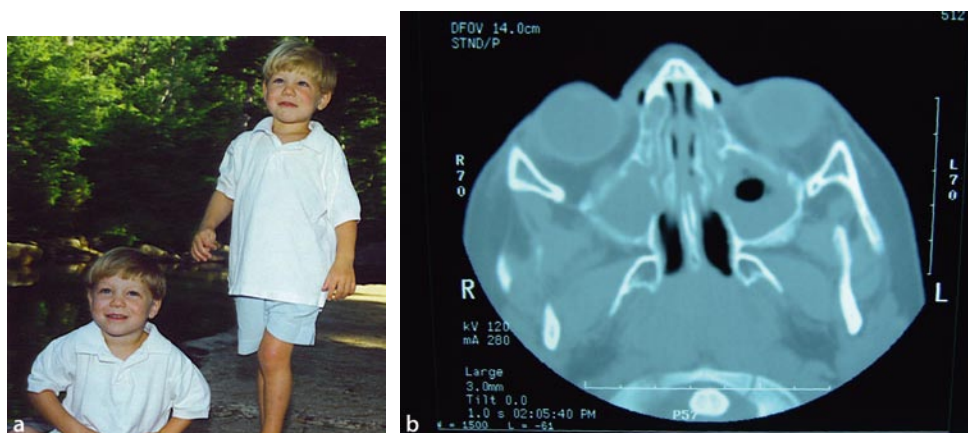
a Child with esotropia acquired at age 2 years (*right*) with his identical twin brother (*left*). b Cause of esotropia ultimately assumed to be severe chronic sinusitis, as seen on CT scan. (Reproduced with permission from the Trans Am Ophthalmol Soc in Ludwig IH, Smith JF (2004). Presumed sinus-related strabismus. *Tr Am Ophth Soc* 102:159–167)
